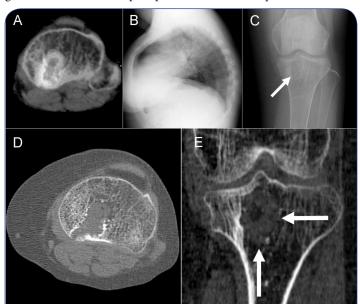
Imaging studies at the first presentation. (A) FDG-PET showing a moderately increased accumulation of tracer (SUVmax, 3.9) in the left proximal tibia (arrows). (B, C) Radiographs of the thoracic spine and left knee before biopsy showing severe spine kyphosis, thin cortices and an osteolytic lesion in the left proximal tibia (arrow). (D, E) CT scans of the left knee showing that the lesion has no marginal sclerosis laterally and distally (arrows)
